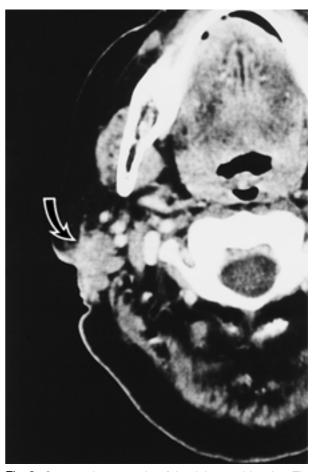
Computed tomography of the right parotid region. The tumor (arrow), an acinic cell carcinoma 2.0 cm in diameter, has recurred at the initial operative site.
